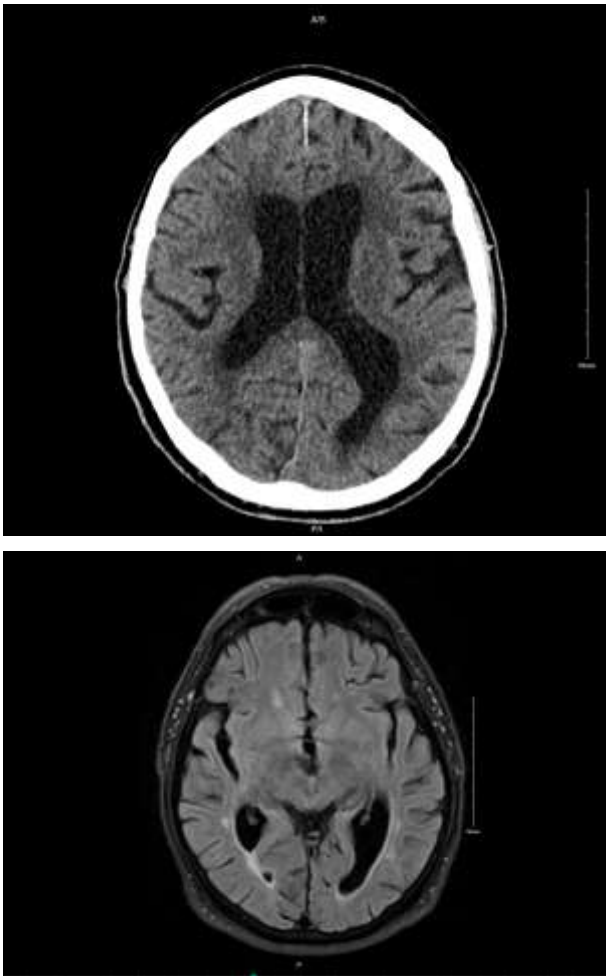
Magnetic resonance imaging (MRI) of the brain revealed an acute cortical and subcortical infarct, confirming the diagnosis
